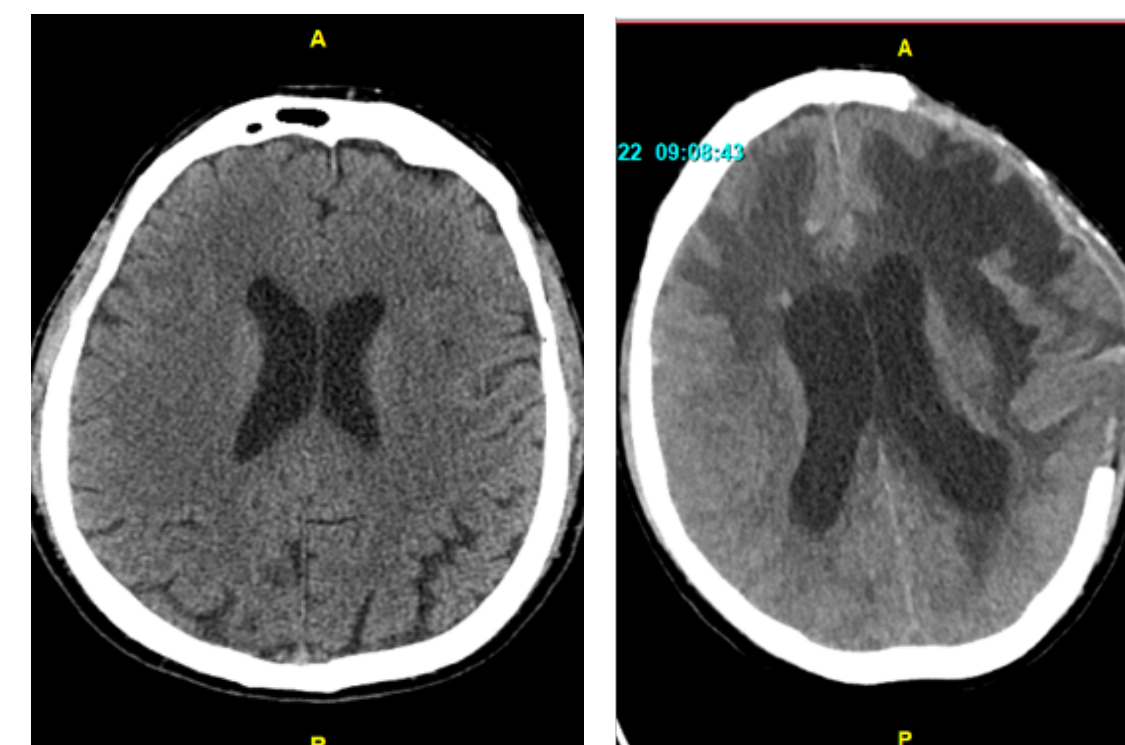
CT head comparison from initial presentation (left) to progression of hydrocephalus and intraparenchymal hemorrhages (right)
